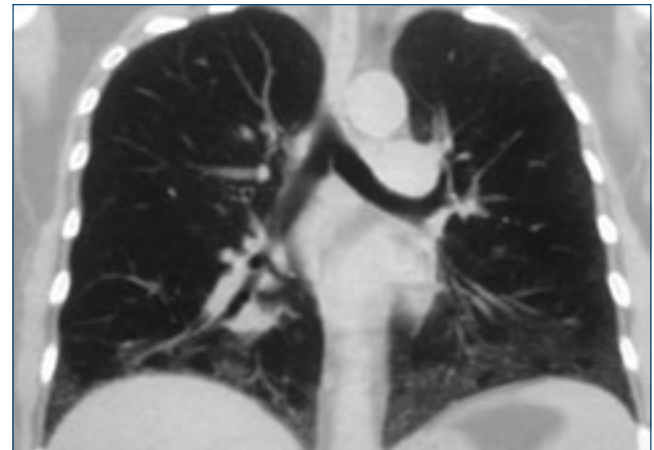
HRCT after eight weeks of discontinuing PEG-IFN and ribavirin and six weeks of systemic steroid therapy showed improvement of the ground glass opacities
